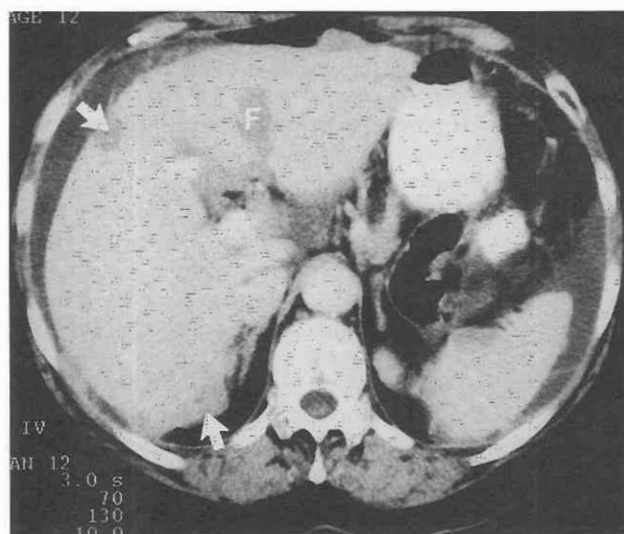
Stage IIIC ovarian cancer. CT scan through the liver and spleen shows multiple surface deposits (arrows). A surface tumor within the cleft of the falciform ligament (F) mimics parenchymal metastasis.
